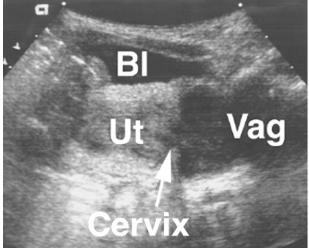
Neonate with ambiguous genitalia. Examination of this patient (A) revealed a phallus, a hypoplastic empty scrotum, and nonpalpable gonads. The karyotype was XX, and abdominal-pelvic ultrasound (B) demonstrated müllerian structures. Serum assays of adrenal steroids established the diagnosis of congenital adrenal hyperplasia. Bl indicates urinary bladder; Ut, uterus; Vag, vagina.
